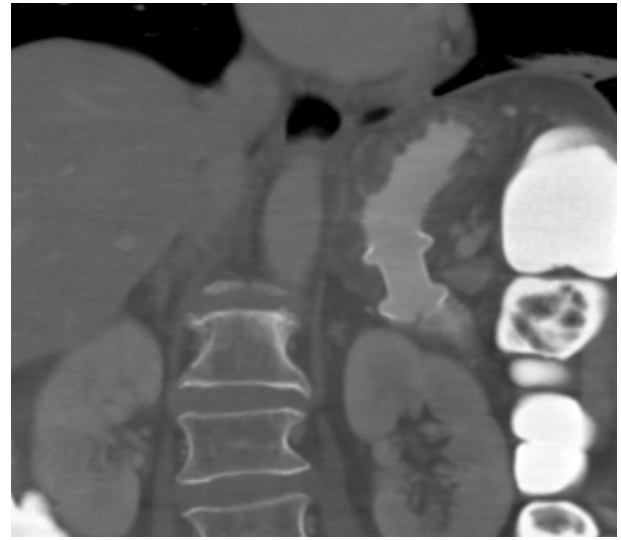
CT image of the gastroenterostomy.
